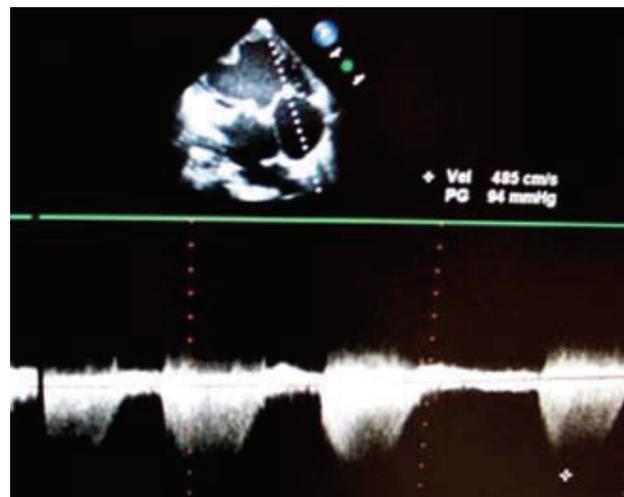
(A) Pulmonary hypertension measured by continuous wave Doppler echocardiography was estimated as >100 mmHg.
